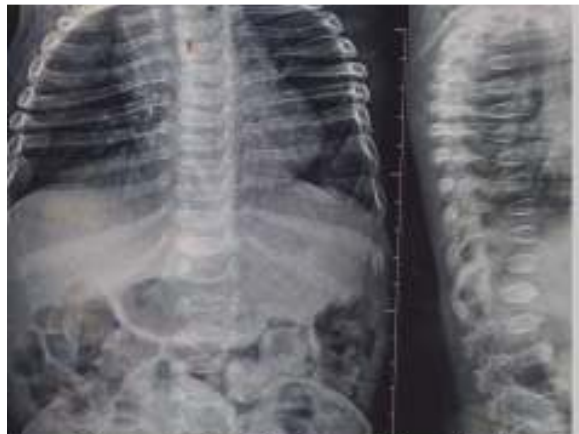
Anteroposterior and lateral x-rays of thoracolumbar spine showing diffuse platyspondyly, anteriorly rounded/wedged vertebral bodies and increased intervertebral disc spaces
